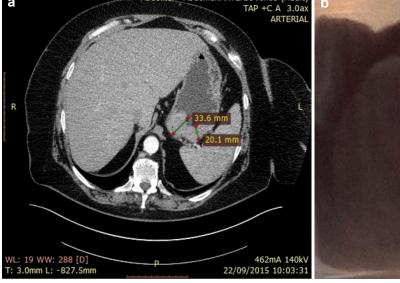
(a) Abdominal CT revealed circumferential thickening of the gastric tuberosity, between 2 cm and 3.5 cm; (b) Polypoid colonic nodule, with irregular contour, smooth surface, centrally depressed, 3.5 cm in diameter.
